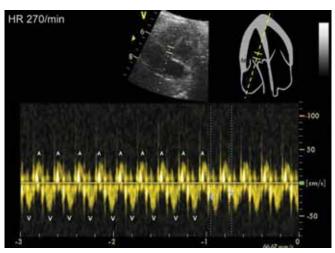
Simultaneous aortic and mitral valve Doppler in a baby shows a long VA (RP) tachycardia
